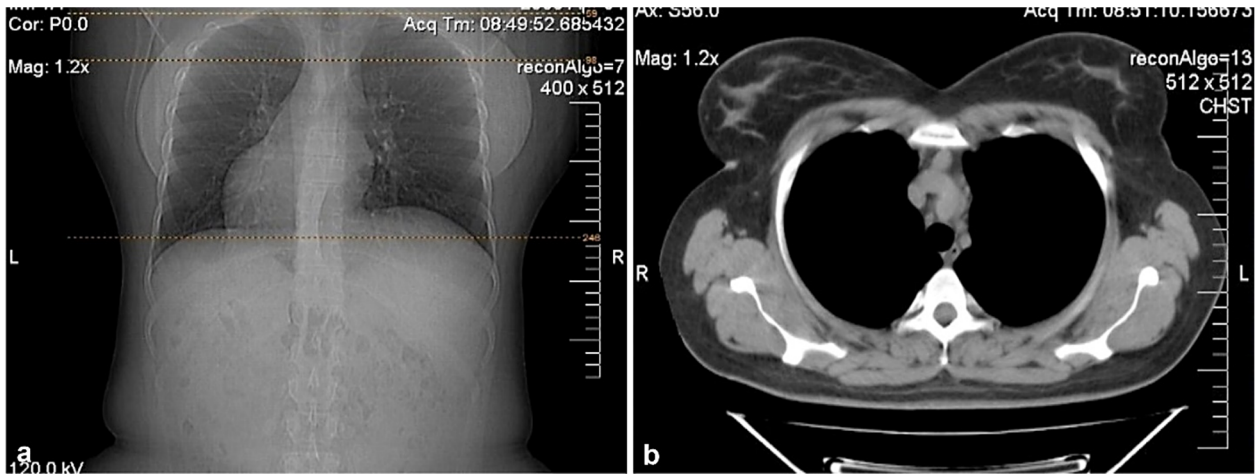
Case No. 2. F, 28-year-old. Thymic follicular hyperplasia, thoracic CT scan: (a) Enlarged heterogeneous thymus (coronal plane); (b) Some nodules may be distinguished from adipose tissue (axial plane). CT: Computed tomography; F: Female.
